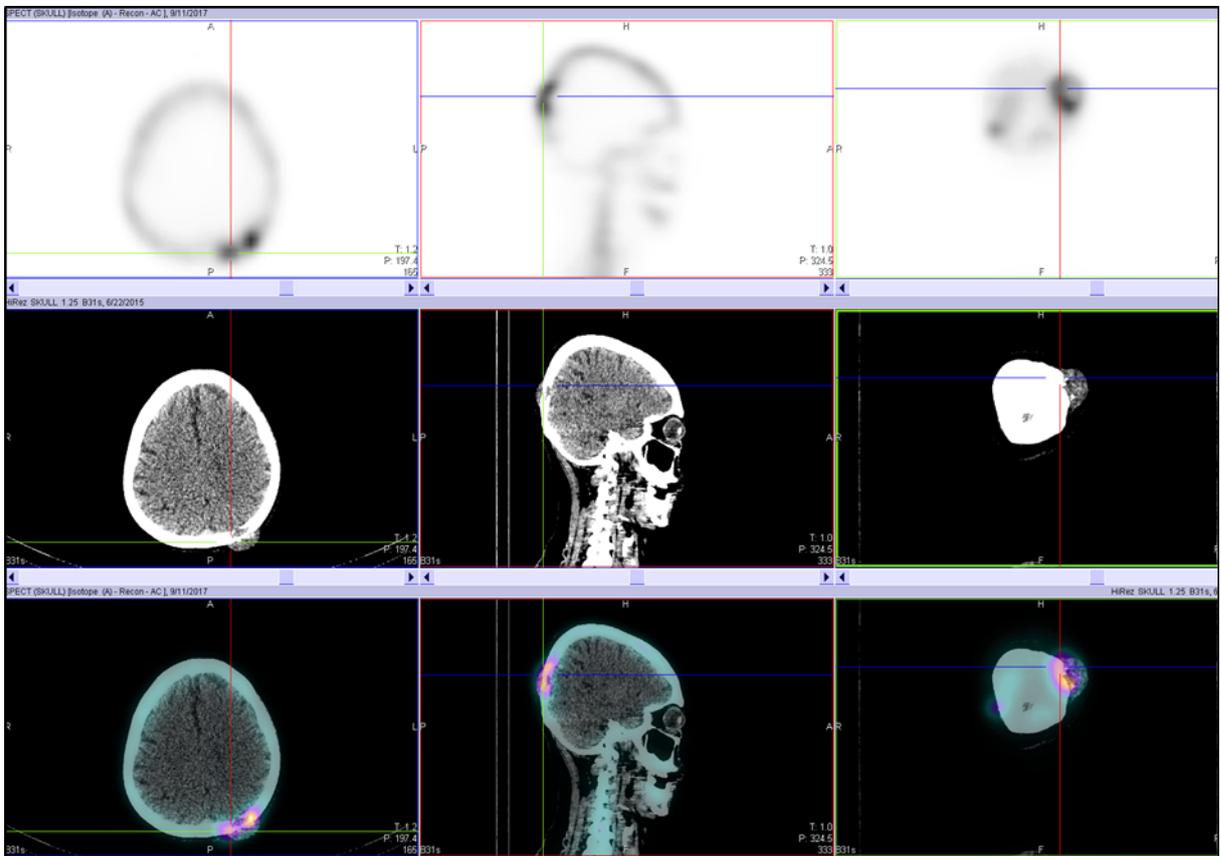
Hybrid SPECT-CT of skull (soft tissue-window) images demonstrate a destructive lesion with soft tissue component at left posterior parietal region no obvious intracranial extension or involvement of the adjacent brain parenchyma.
